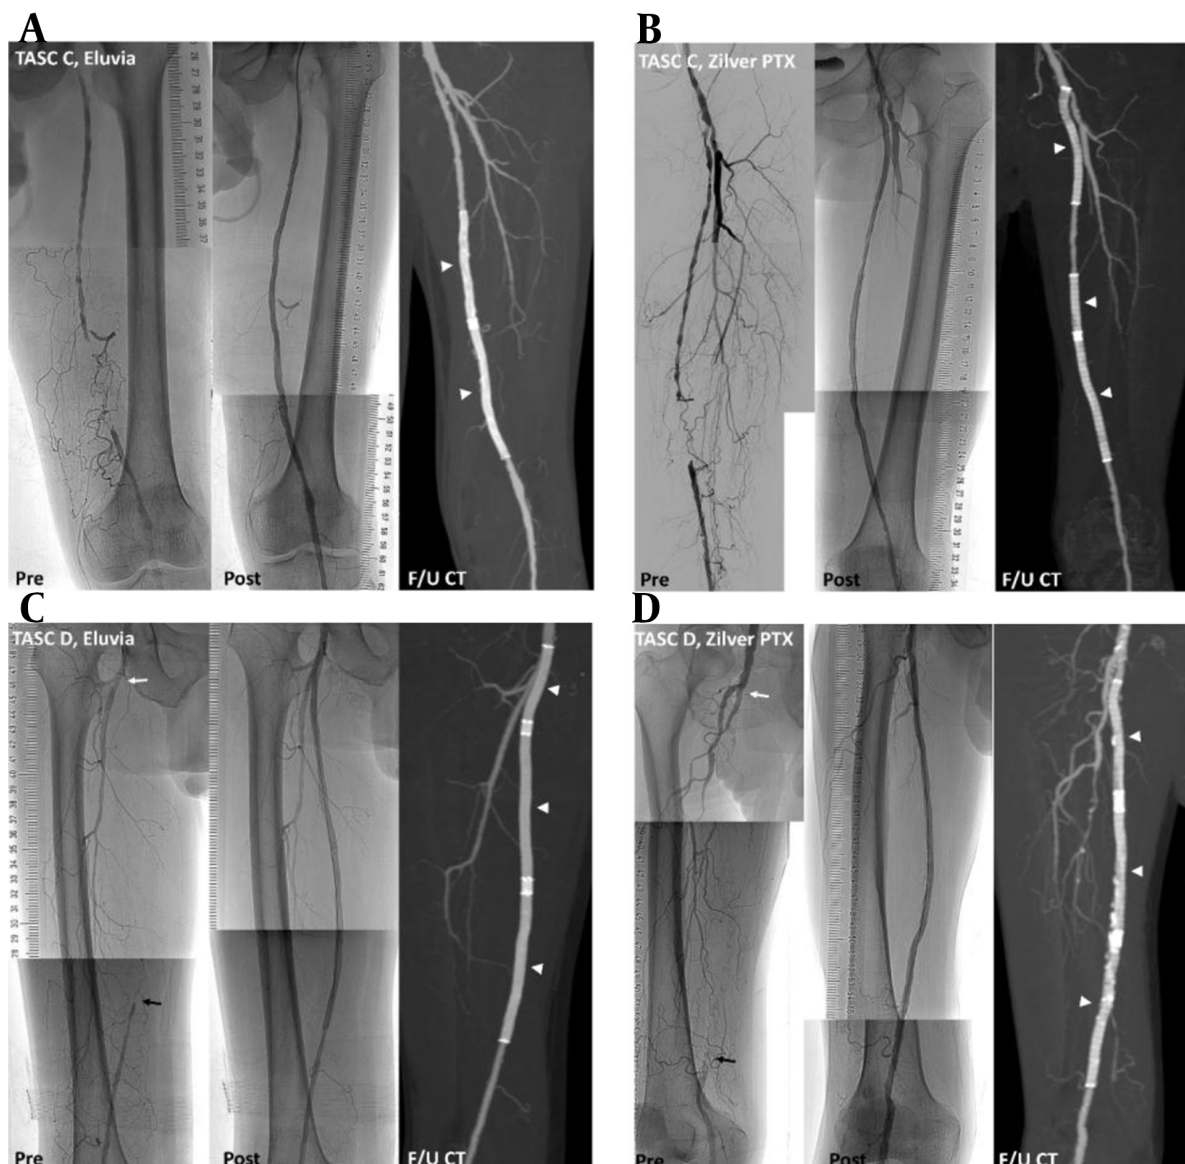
Representative cases successfully treated with paclitaxel-eluting stents (PES). Preprocedural angiography, postprocedural angiography, and follow-up CT scans acquired six months after the procedure (arrow heads) show preserved stent patency. A, A trans-Atlantic inter-society consensus document (TASC) C lesion in a 62-year-old male patient with ulcer and pain in the left big toe, treated with two Eluvia stents. B, A TASC C lesion in a 53-year-old male with 500-m claudication, treated with three Zilver PTX stents. C, A TASC D lesion in a 78-year-old male patient with 50-m claudication and total occlusion from the ostium (white arrow) to the distal superficial femoral artery (black arrow), treated with three Eluvia stents. D, A TASC D lesion in a 75-year-old male patient with 30-m claudication and total occlusion from the ostium (white arrow) to the proximal popliteal artery (black arrow), treated with three Zilver PTX stents.
